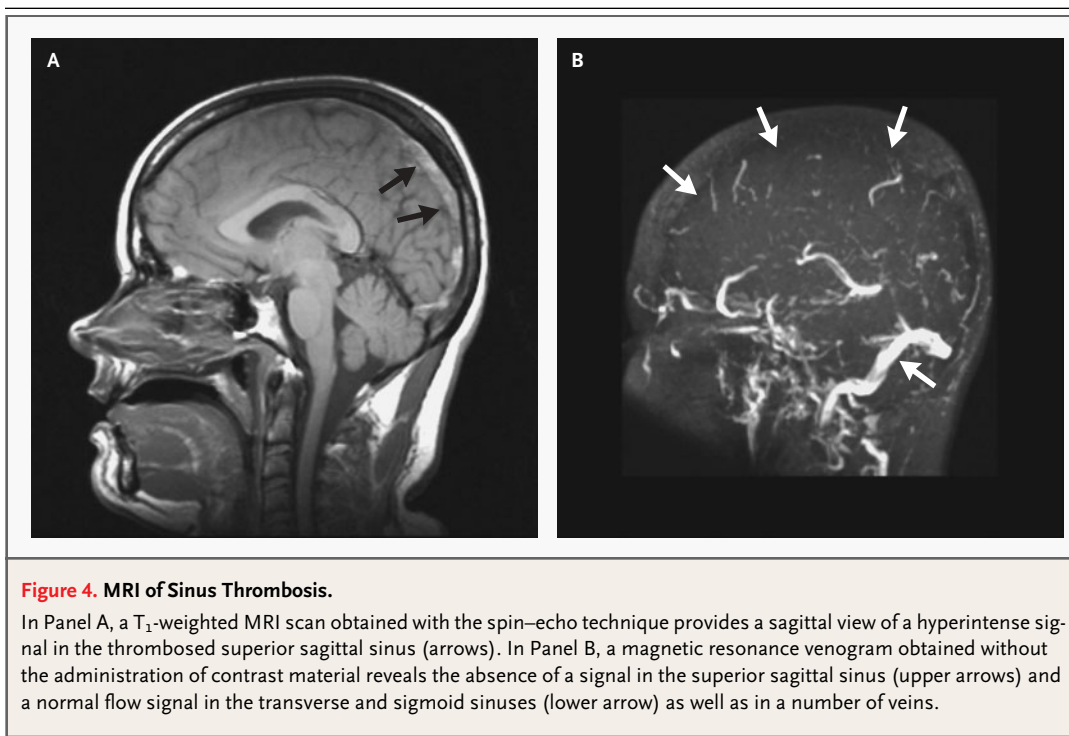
MRI of Sinus Thrombosis.
